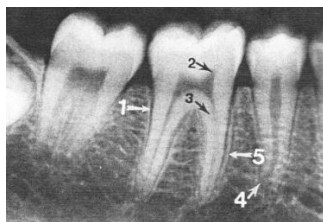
Intraoral periapical radiograph of teeth at lower right jaw [28].
